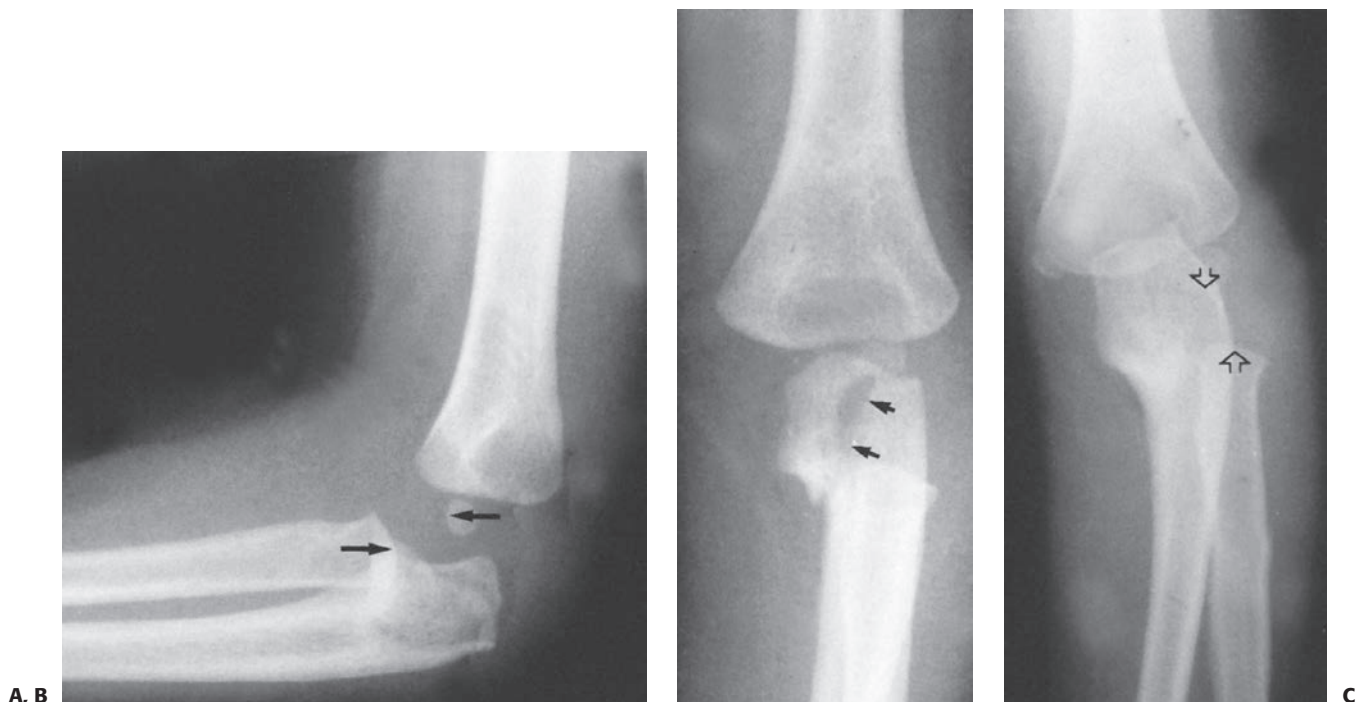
Type II lesion. The typical radiographic findings include A: A posterior dislocation of the radial head (arrows) and (B) A proximal metaphyseal fracture, which may extend into the olecranon (arrows). C: The radial head dislocation also may be posterolateral (arrows).
